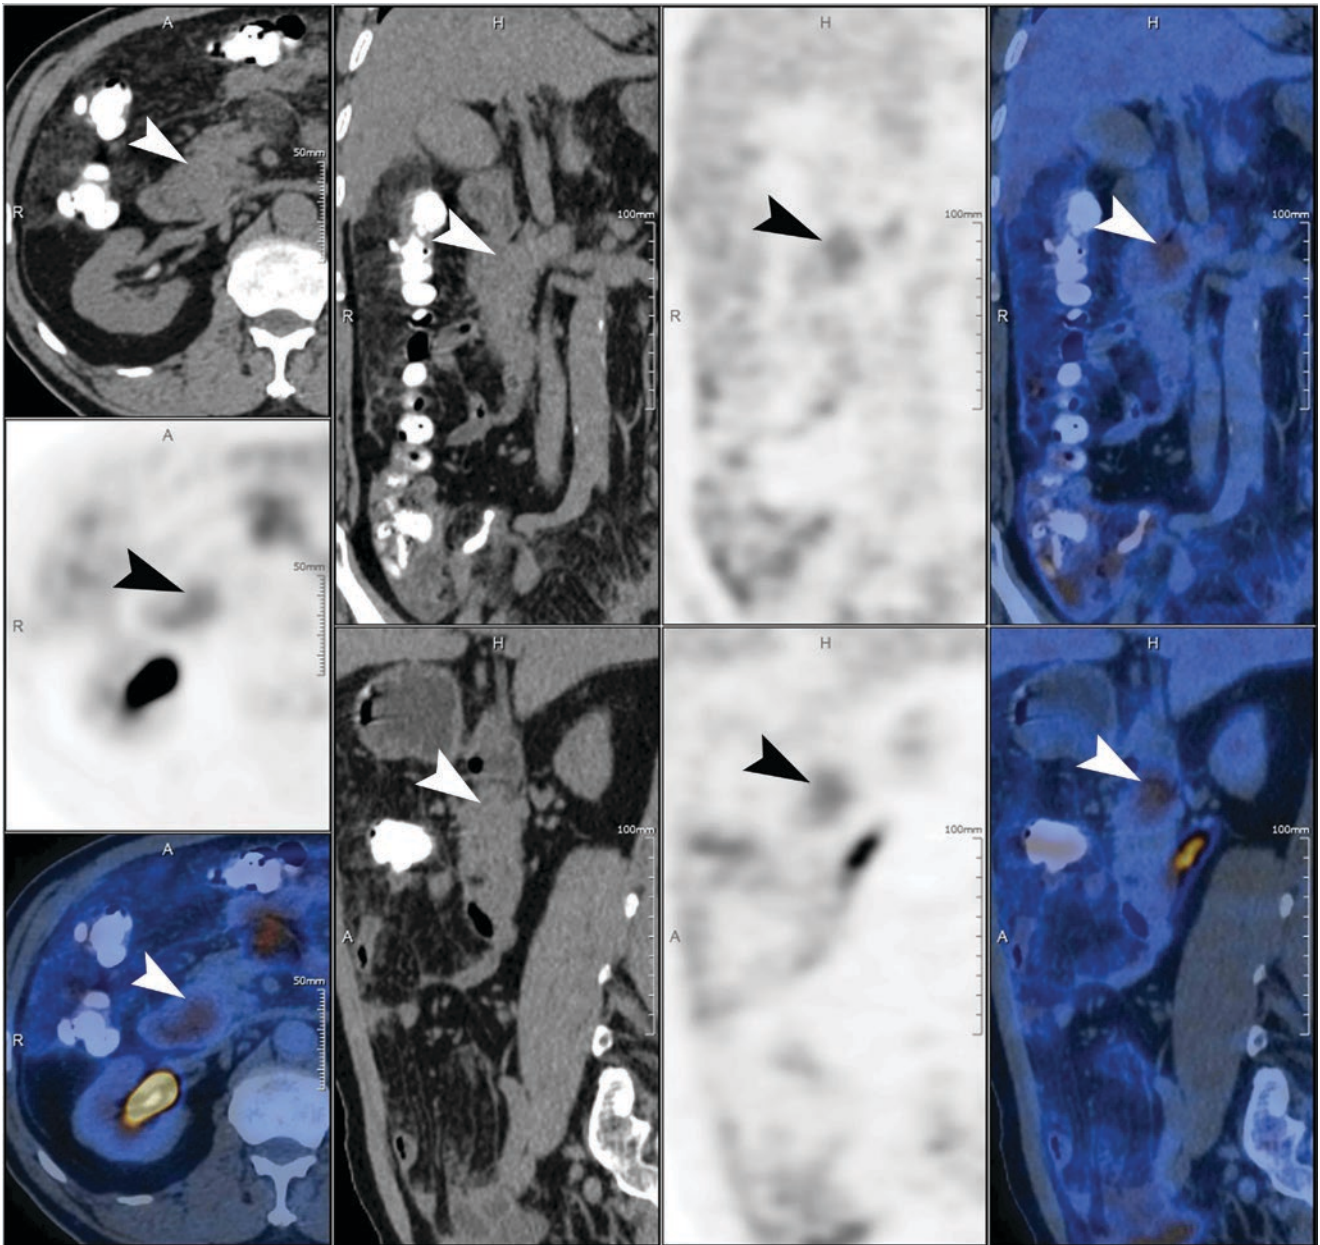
Myeloid sarcoma of the descending part of the duodenum. The PET/CT images demonstrate a 34.4 × 26.4-mm soft-tissue mass with intense accumulation of 18FDG (myeloid sarcoma; SUV_{max} 6.7) within the lumen of the descending part of the duodenum (solid arrowhead)
